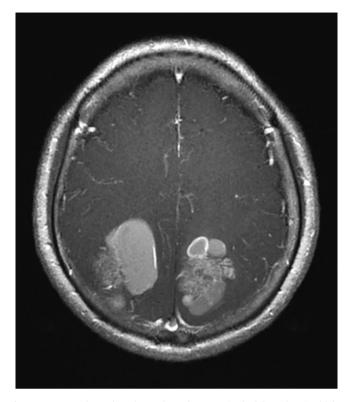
Contrast-enhanced axial MRI showed a tumor in the bilateral parietal lobe.
